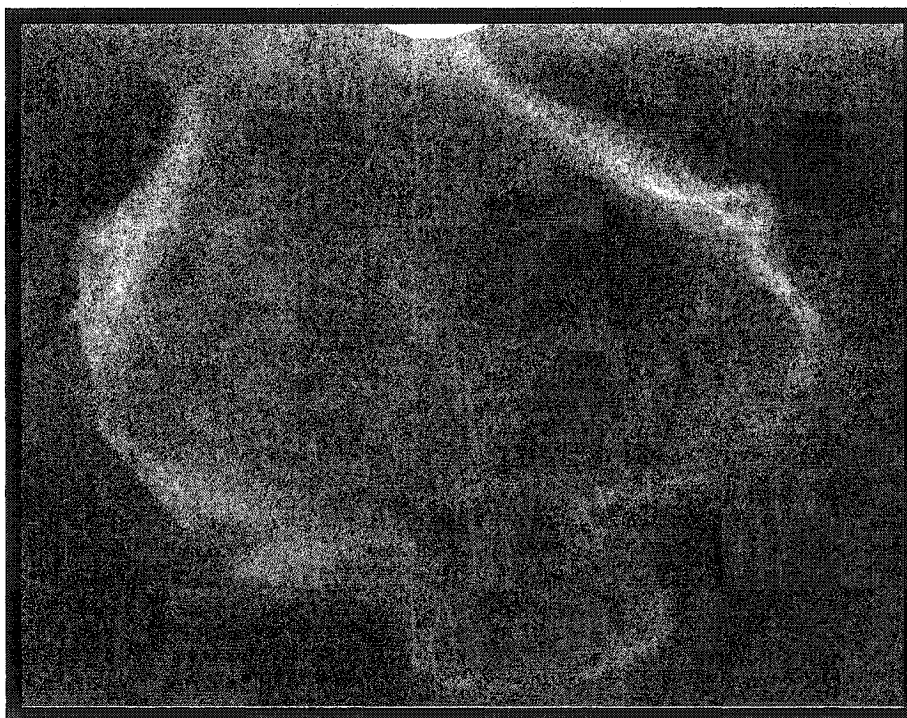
Radiograph of Open and Plaster of Paris defects at 12 weeks.
